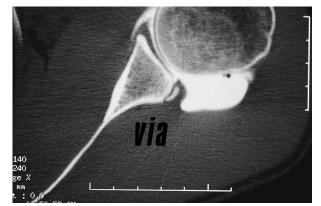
Posterior glenoid rim fracture on CT-arthrography.
